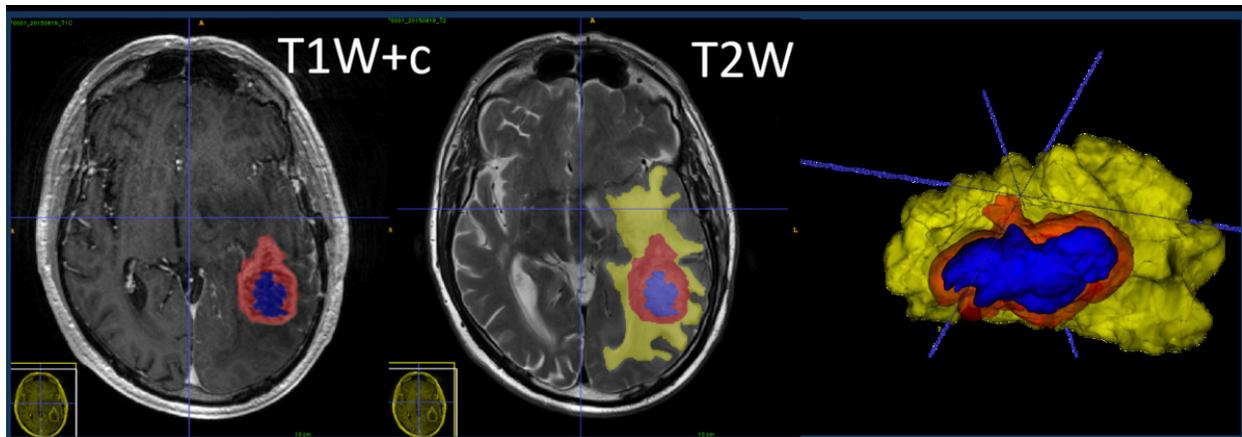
Co-registration of T1-weighted post-contrast and T2-weighted MRI images with segmentation of enhancing tumour (red) and peritumoural oedema (yellow). Volumes of interest created (right).
